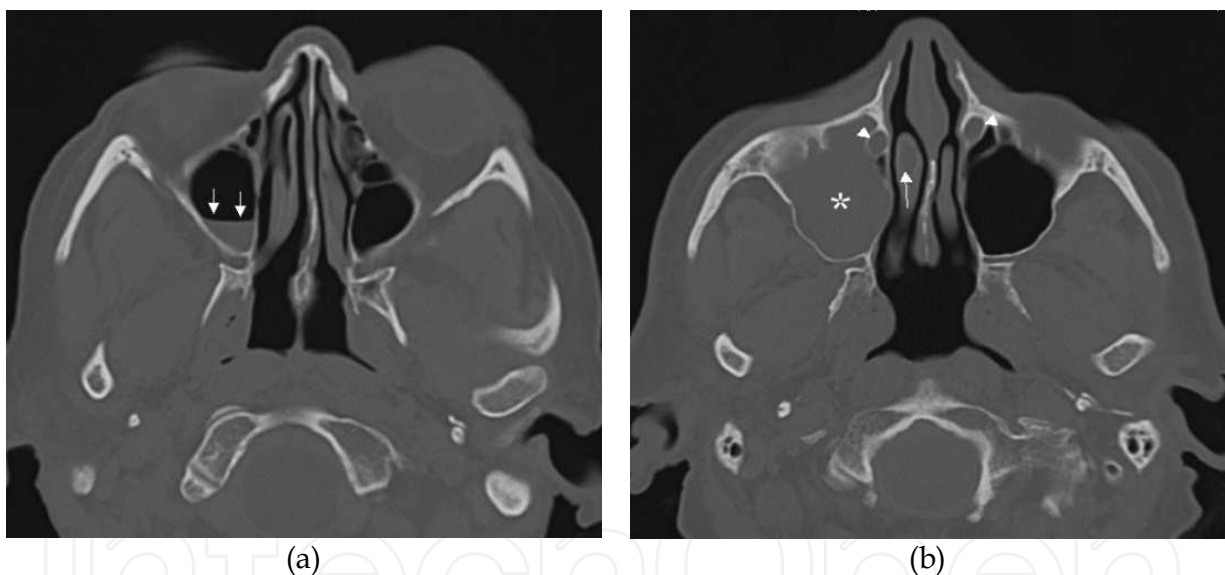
(a) Axial CT shows incidental finding of an air-fluid level (arrows) in the right maxillary sinus in a patient undergoing cerebral CT. There is no sclerotic bone thickening and hence no indication for follow-up. (b) Axial CT shows incidental total opacification of the right maxillary sinus (asterisk) without sclerotic bone thickening. Unless clinical symptoms of a acute sinusitis, no action to this finding is needed. Notice also opacified right concha bullosa (arrow) and normal fluid filled lacrimal ducts (arrowheads)
